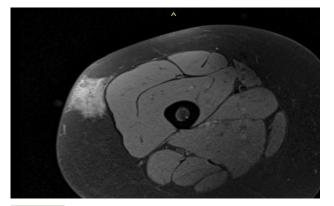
T1 MRI transverse plane of the lesion. A regional thickening of the skin above the lesion was noticed.
